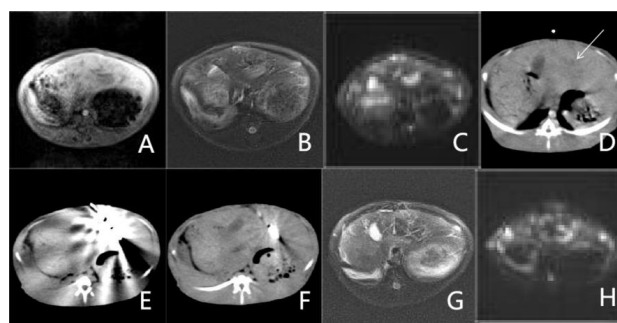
CT guided microwave ablation. A, B, C: Preoperative T1WI, T2WI, DWI images show that the lesion is located at the left lobe of liver. D: Preoperative CT image, white arrow shows the tumor lesion, which is of slightly low density. E, F: Intraoperative CT images show that the high density ablation needle tip passes through the focus. G, H: Postoperative T2WI and DWI images show that T2WI and DWI signal of lesion changed immediately from high signal in Figure B,C to low signal.
